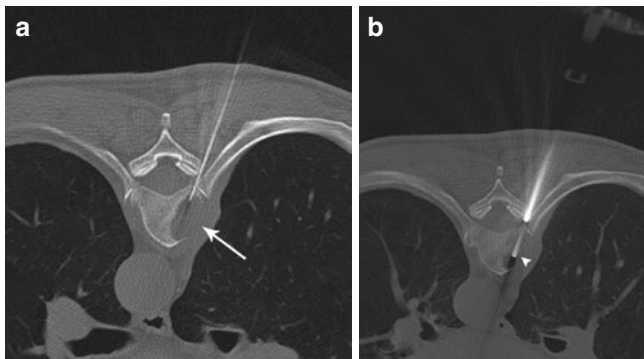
(a) CT-guided bone biopsy of a purely lytic metastatic lesion involving the vertebral body of TH7 (*arrow*). A 22 G spinal needle for local anesthesia of the whole pathway. (b) A coaxial bone biopsy system is introduced using a right-sided costovertebral approach (*b, arrowhead*)
